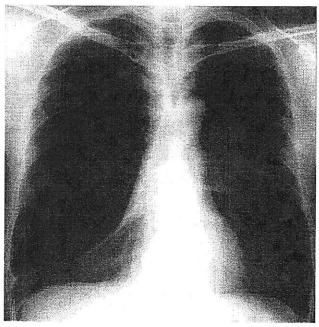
Chest radiograph showing a large bulla in the right hemithorax.
